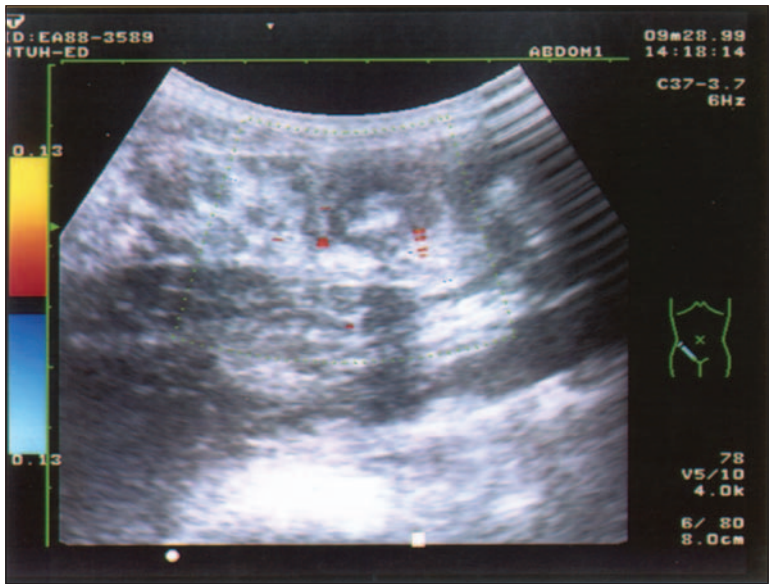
Color Doppler sonography shows increase vascularity in periappendiceal fluid.
